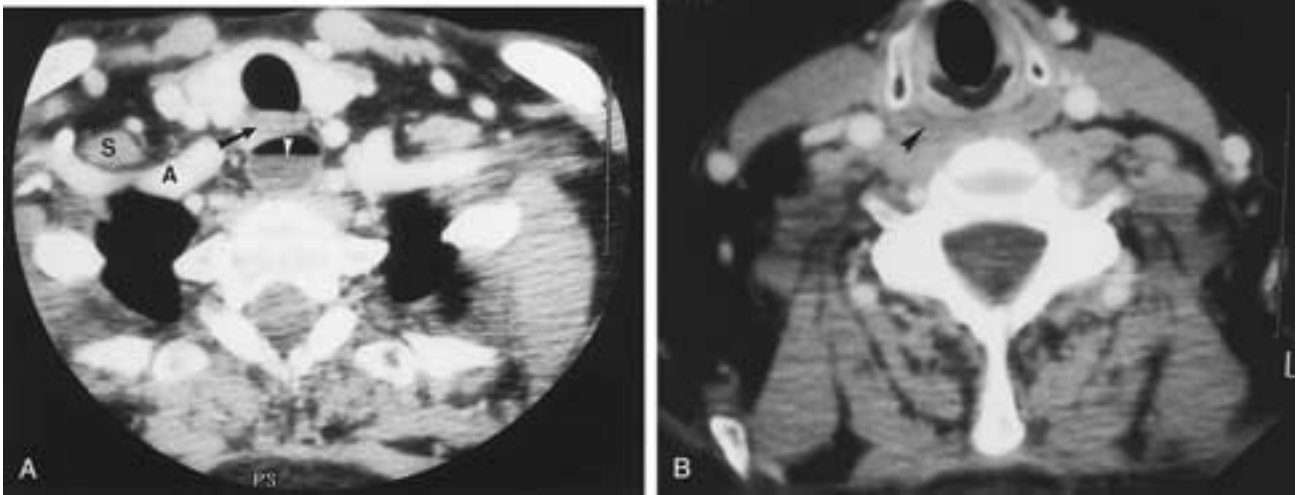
Zenker's diverticulum. Axial CT. A, An air-fluid level (*arrowhead*) is seen within the diverticulum. The actual esophagus (*arrow*) is seen just anteriorly. *A*, Subclavian artery; *S*, anterior scalene. B, More superior scan shows the intact pharyngeal wall (*arrowhead*) at the level close to the cricopharyngeus muscle. The abnormality (not shown) actually extends through the various fibers of the muscle.
